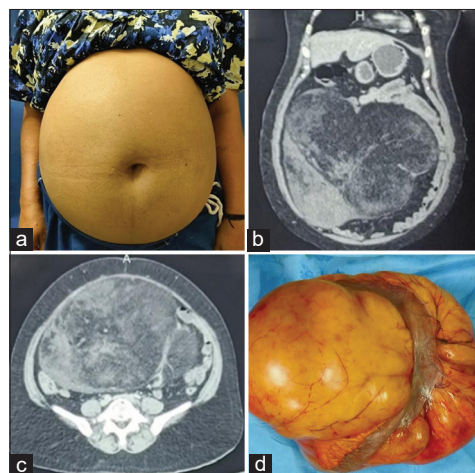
Clinical, radiological, and surgical findings of the patient. All images are original images taken from the patient with appropriate consent. (a) Pre-operative clinical image showing a distended abdomen; (b) Coronal contrast-enhanced computed tomography (CT) scan showing a large, well-defined heterogeneous mass occupying the abdominal cavity; (c) Axial contrast-enhanced CT scan; (d) Intraoperative image showing the resected tumor
